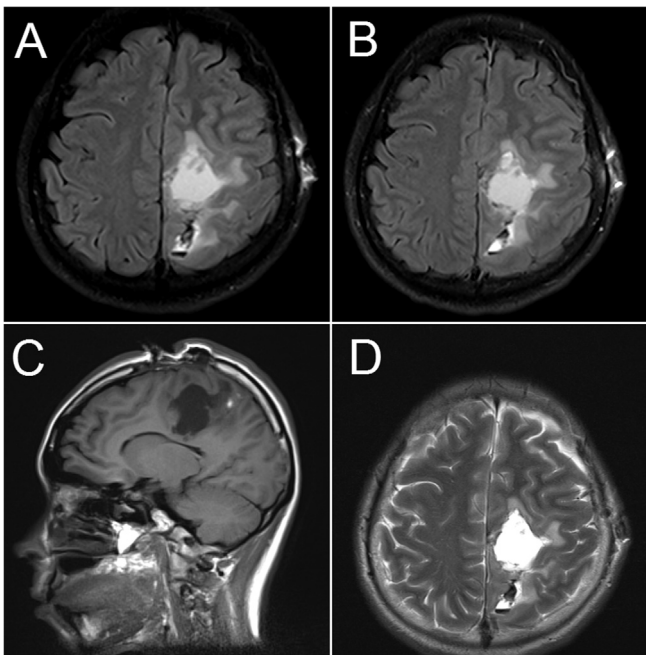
Post-operative MRI scan. Axial FLAIR sequence pre- (A) and post-contrast (B). C, T1WI sagittal sequence; D, T2WI axial.
